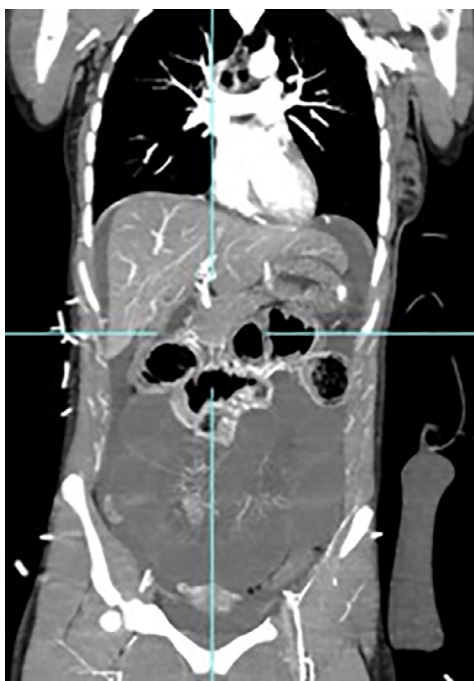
CT scan shows signs of sub-total small bowel ischemia and mesenteric venous gas.
